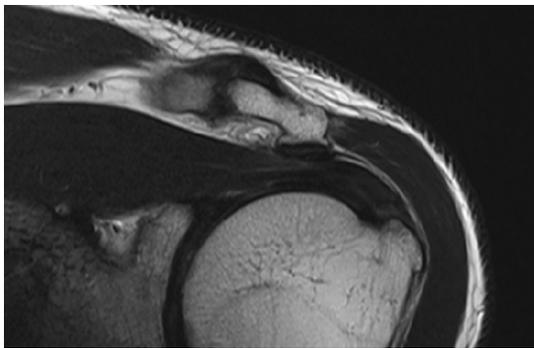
The spur was defined as a trapezoid- or tetragon-shaped bony protrusion with a peak that extended more than 3 mm downward from the baseline drawn along the acromial undersurface on the coronal view of MRI (T2 weighted image)
